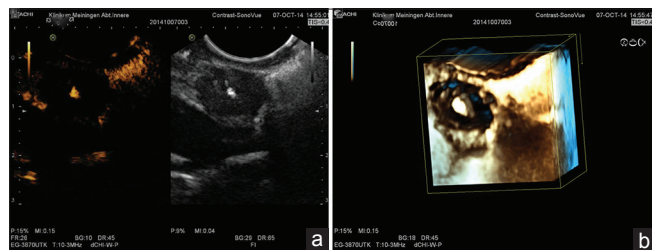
Typical lymph node in the mediastinum of a patient with tuberculosis; (a) low-mechanical index contrast-enhanced endosonography after injection of 4.8 mL Sonovue shows no lymph node perfusion but a central calcification; (b) three-dimensional reconstruction of the same contrast mode shows the lack of perfusion and the calcification more pronounced
